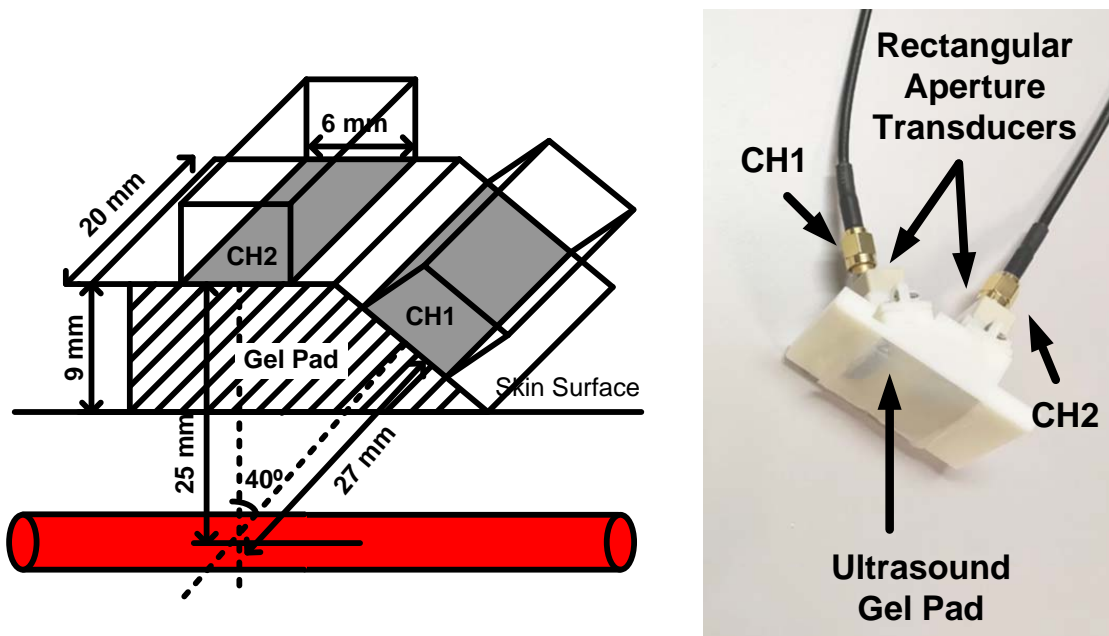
Second probe design for widebeam insonation with rectangular apertures for motion-tolerant ultrasound measurements used in the Valsalva maneuver study [70] and NEWEST study.
